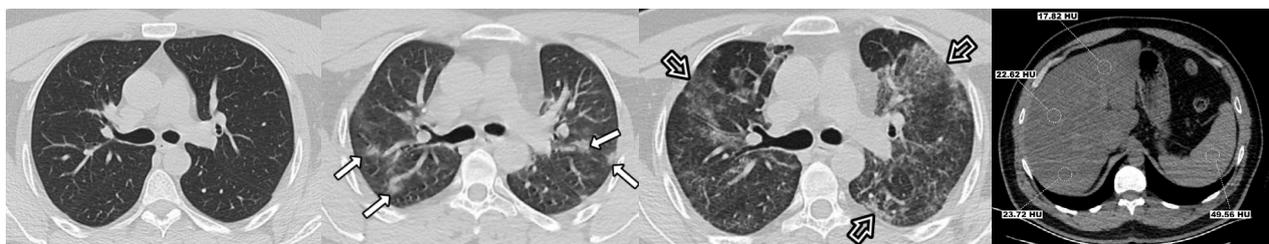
A 43-year-old male patient was admitted to our hospital with complaints of fever, cough, and sore throat. RT-PCR test was positive. a) Unenhanced chest CT at admission was normal (CT-SS=0). His treatment was started as an inpatient. However, when the patient's complaints increased, follow-up CTs were performed and he was admitted to the ICU. b) On the second CT, areas of peripheral weighted ground glass density (GGO) (white arrows) were observed in both lungs (CT-SS= 8). c) On the third CT, there was an increase in GGOs and transformation into areas of crazy paving patterns (open arrows) in both lungs. The patient who was treated was discharged with recovery. d) Quantitative analysis of liver (mean 21.39 HU) and spleen (49.56 HU) density was performed (CTL/S= 0.43). The liver was hypodense relative to the spleen
